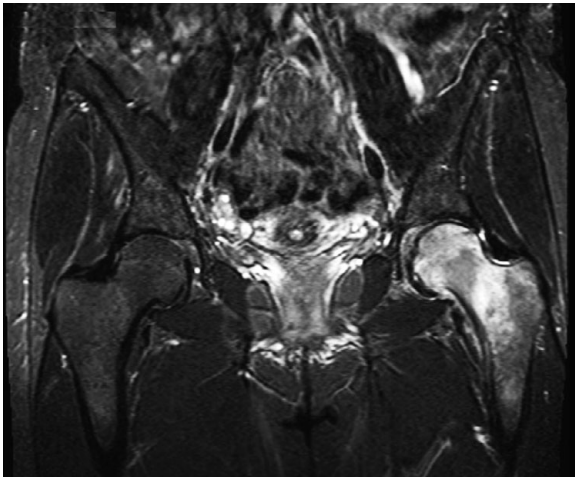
T2 sagittal MRI pelvis
